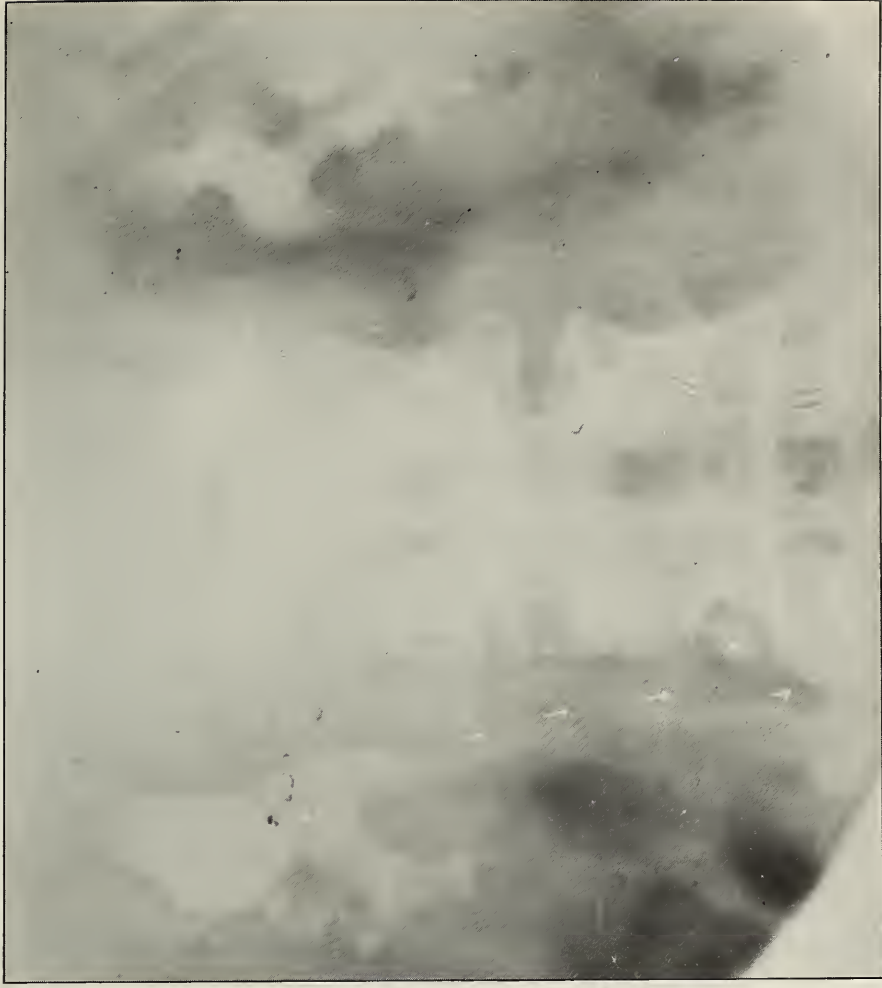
X-ray No. 13018, b. Colloidal silver locates a shadow in the renal pelvis and shows distention of the upper calyx, also rules out lower shadow. Left kidney also injected and shows a normal pelvis.
